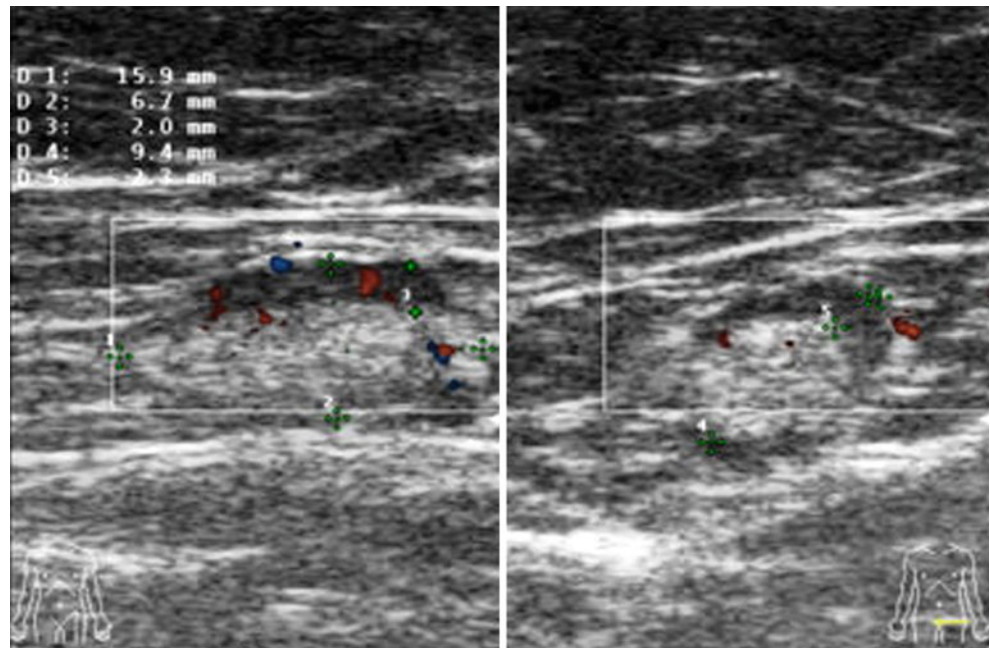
Chronological development of a focal nodal metastasis. Directional power Doppler image (a, b). Changes observed over a time period of 3 weeks (patient had first refused to undergo fine-needle aspiration cytology or operation)
